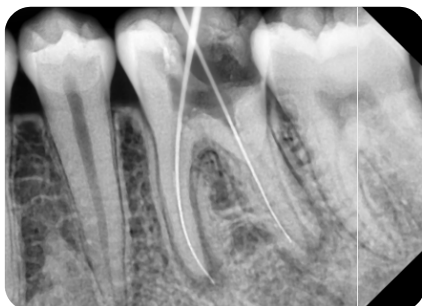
Radiograph taken with a more mesial angulation
